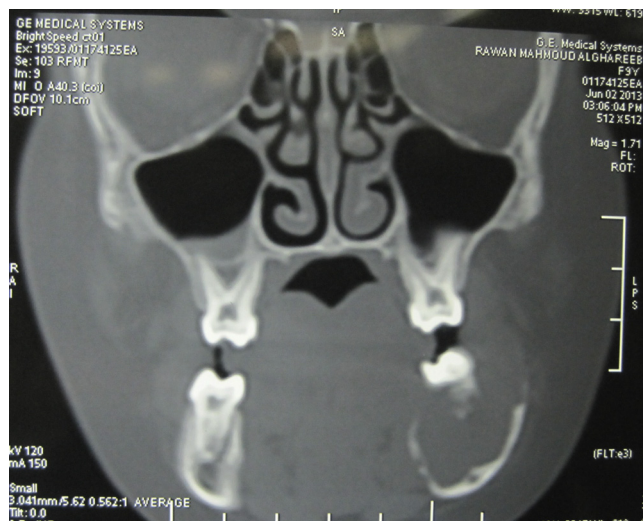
Coronal CT cuts showing bucco-lingual extension and thin rim of inferior border remaining extension).
